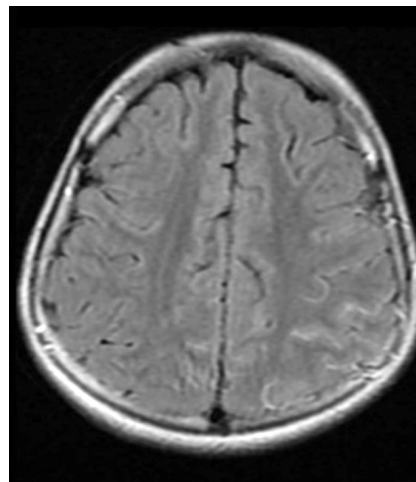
A brain MRI conducted during the patient's readmission showed enhancing signal abnormality in some of the cerebral sulci, more so on the left and greatest along the left parietal lobe; it was notably more prominent than on the previous scan.
